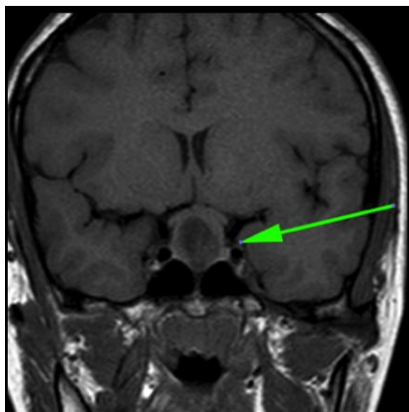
MRI image showing T2 hyperintense lesion in sella and suprasellar region replacing pituitary gland
